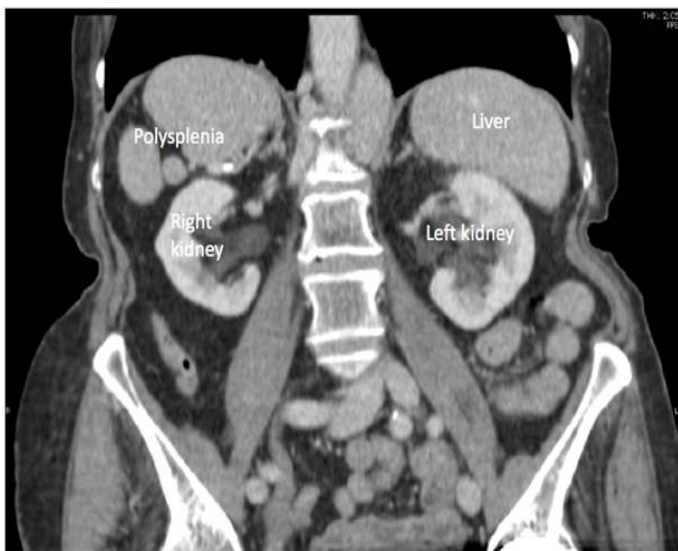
Coronal single slice computed tomography through the upper abdomen. The liver is present on the left side and there are three spleens on the right side. The colon is located totally on the right side.
